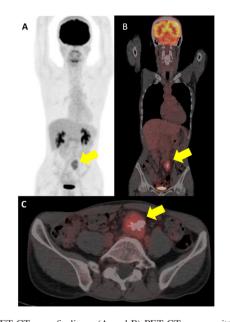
PET CT scan findings. (A and B) PET CT scan sagittal. (C) PET CT scan axial; the arrow shows the 50x30 mm space-occupying lesion with hypermetabolic activity (SUVmax at 4.1) in the pelvic retroperitoneal. PET CT, positron emission tomography computed tomography.
